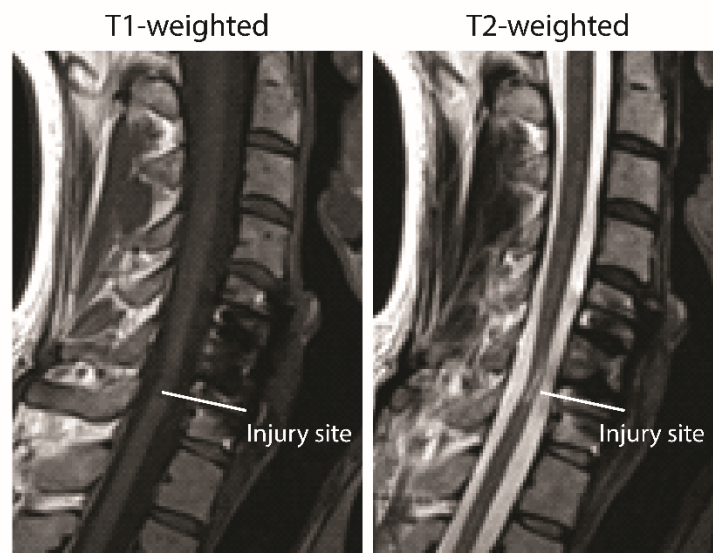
Examples of conventional T2-weighted MRI in sagittal view from a SCI patient. Note that these images provide information regarding the level, type and extent of the injury. T2-weighted image is generally considered the best diagnostic tool due to its higher contrast between the parenchyma and the lesion. However, these acquisitions are not sensitive to the underlying microstructural changes and therefore are not good predictors of long-term outcomes.
